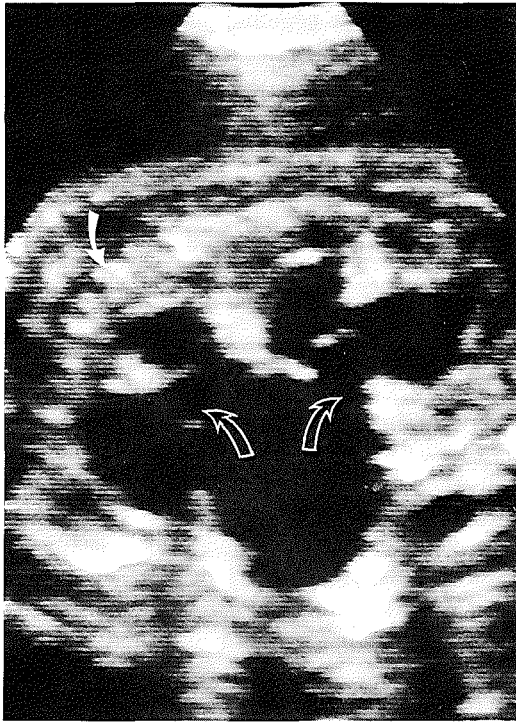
Hydronephrotic kidney. Prenatal ultrasonographic appearance (gestational age 26 weeks). Dilated pelvis and calyces (open arrows) with normal renal parenchyma (closed arrow)
